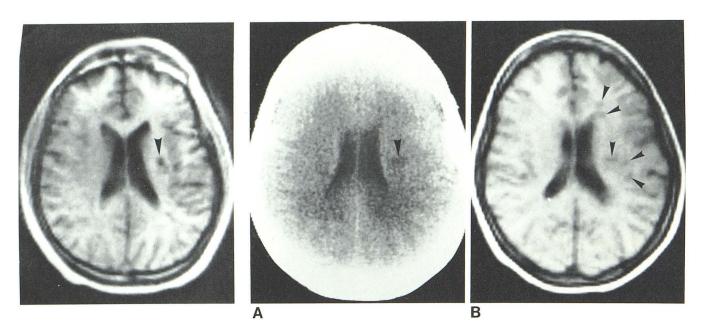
Infarction, 25-year-old man with abrupt onset of right-sided weakness. CT examination was normal. Transverse NMR scan. Small white-matter infarct (*arrowhead*).
